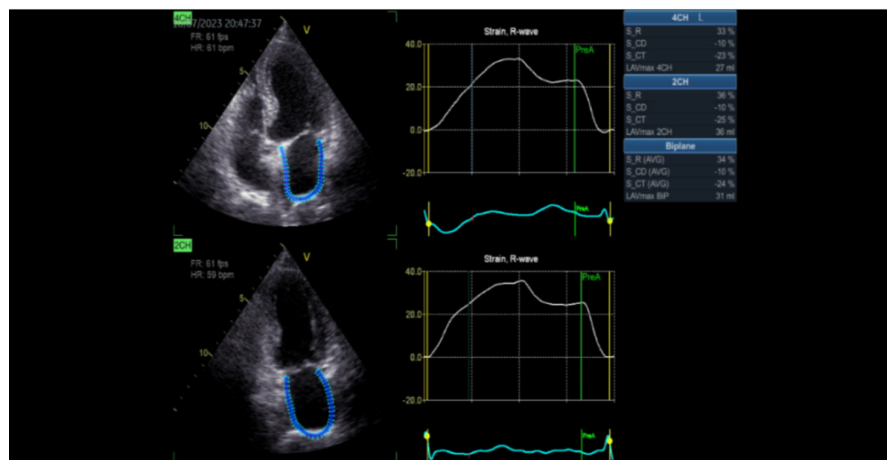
LA strain in apical 4 and apical 2 chamber views
